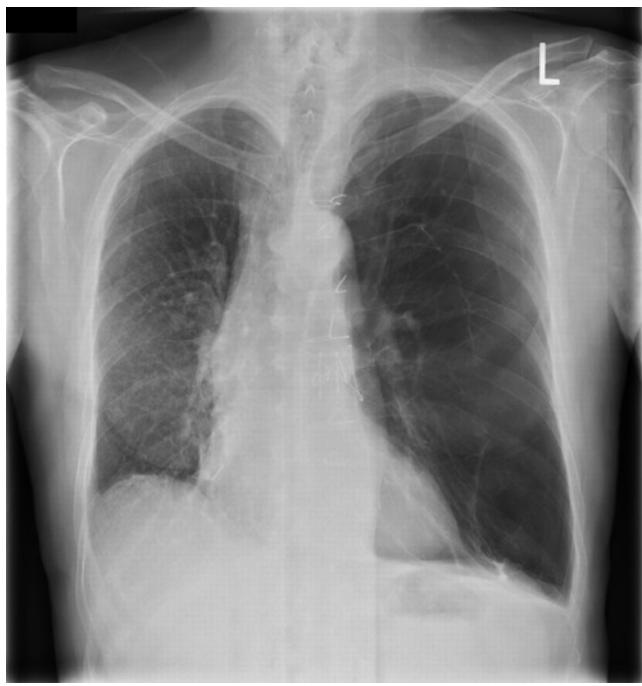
Chest X-ray of a recipient of a right single-lung transplant.
